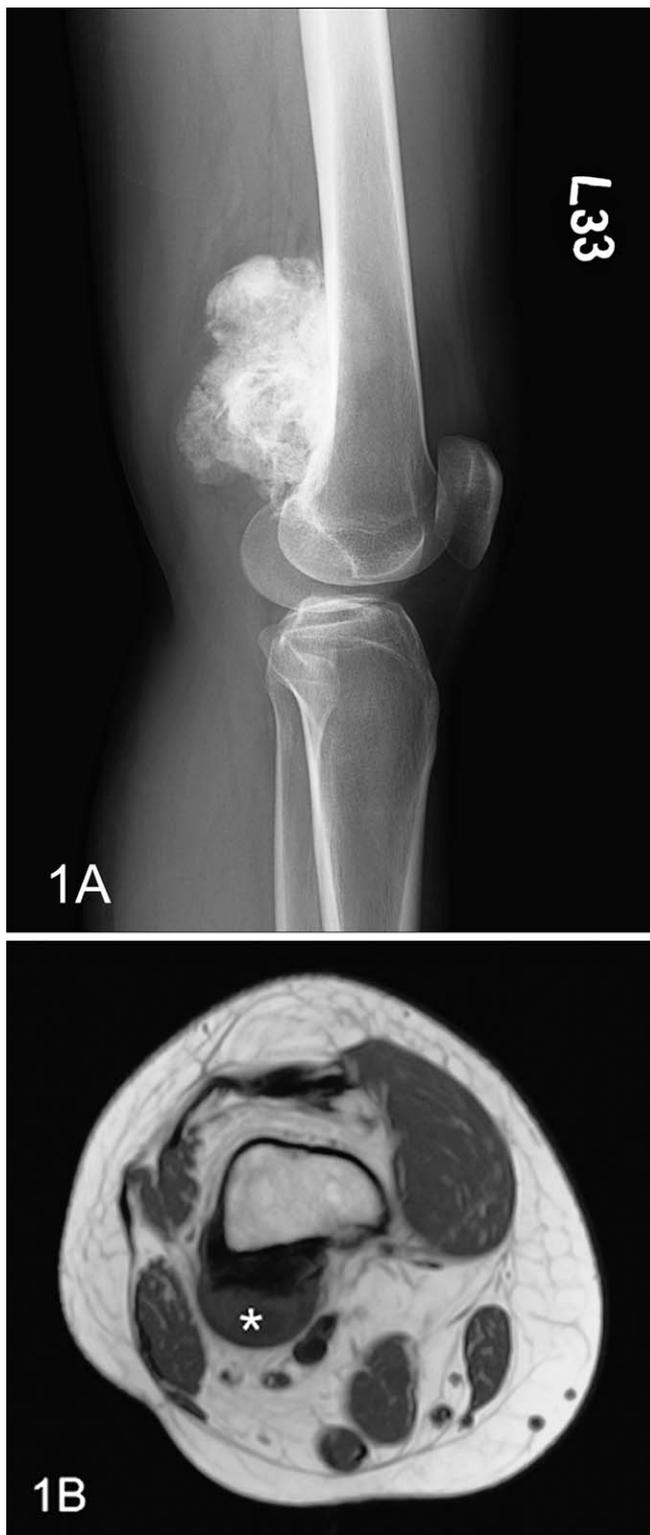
A, Lateral radiograph of the left knee of a 33-year-old woman shows a radiodense, lobulated mass over the posterior distal femur. The tumor has an irregular mineralized pattern and attaches to the underlying cortex with a broad base. The periphery of the tumor is less radiodense than the center. B, Magnetic resonance axial scan of a T1-weighted image of the right distal femur from a 39-year-old woman reveals a protruding mass arising from the posterior cortex of the distal femur with low signal intensity. It is covered by a cartilage cap (asterisk). The medullary cavity is not involved.
